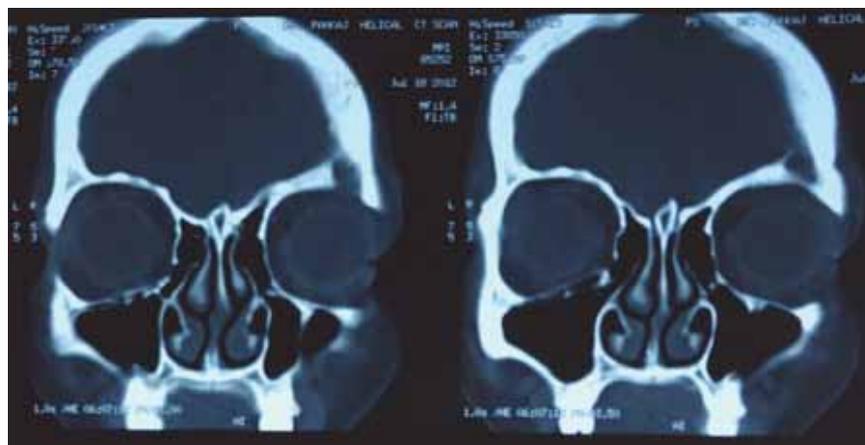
Pretreatment coronal non-contrast and post contrast axial CT sections revealing sclerotic thickening of left superior orbital wall surrounding a lytic area through which sinus tract is outlined by contrast extending in extra cerebral intracranial anterior frontal region with thickening of adjacent frontal skull vault
